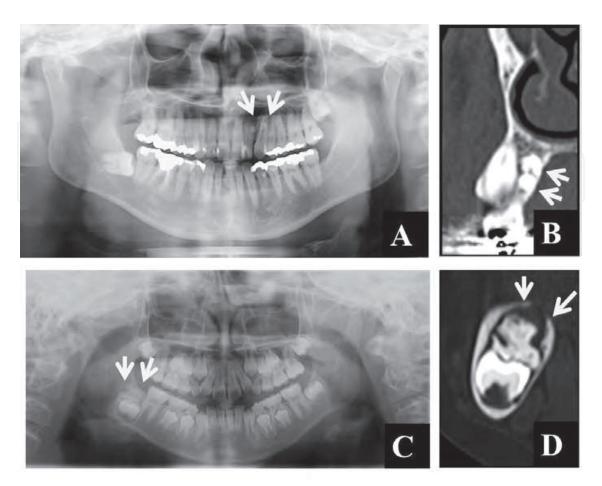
Panoramic radiograph image (A) and oblique sagittal CT image (B) of compound odontoma (arrows). Panoramic radiograph image (C) and oblique coronal CT image (D) of complex odontoma (arrows).
